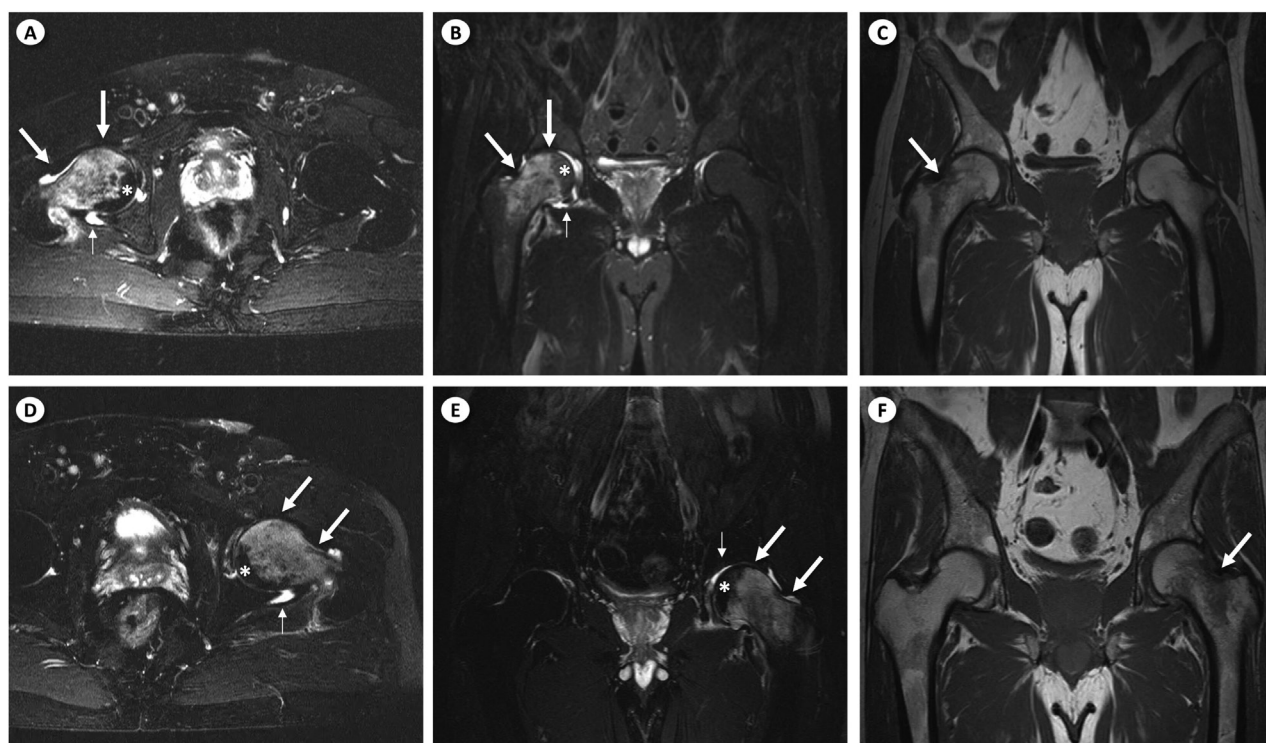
(A) Axial and (B) coronal T2-weighted fat-saturated magnetic resonance (MR) images of the hips demonstrate diffuse heterogeneous signal hyperintensity affecting the bone marrow of the right femoral head, neck, and part of the intertrochanteric region (thick arrows), indicating bone marrow edema. A mild joint effusion is also noted (thin arrows). (C) Coronal T1-weighted MR image of the hips displays areas with partial loss of the normal fatty marrow signal in corresponding bone marrow edema areas of the right hip (thick arrow), which is most evident when compared to the contralateral normal side. (D) Axial and (E) coronal T2-weighted fat-saturated magnetic resonance (MR) images of the hips from a different MR examination demonstrate diffuse heterogeneous signal hyperintensity affecting the bone marrow of the left femoral head, neck, and part of the intertrochanteric region (thick arrows), suggestive of bone marrow edema. A mild joint effusion is also noted (thin arrows). (F) Coronal T1-weighted MR image of the hips displays areas with partial loss of the normal fatty marrow signal in corresponding bone marrow edema areas of the left hip (thick arrow), likewise most evident when compared to the contralateral normal side. These findings are identical to those described for the right hip. Note that in both hips, the medial part of the femoral head is spared (asterisk), an imaging finding characteristic of transient osteoporosis of the hip (otherwise known as transient bone marrow edema syndrome of the hip).
